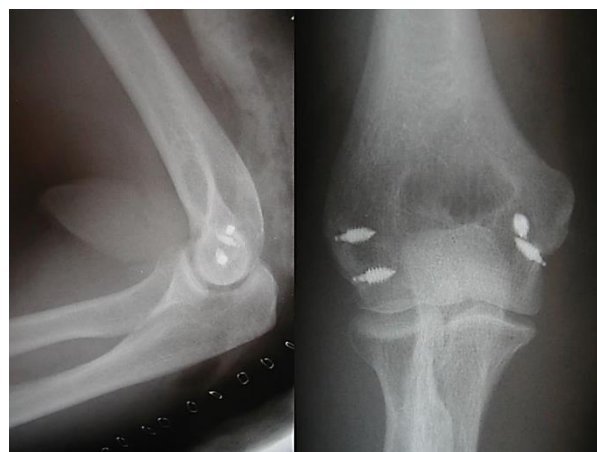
Anteroposterior and lateral radiographs of the same patient after open reduction and soft-tissue repair with suture anchors demonstrating a concentric joint space
